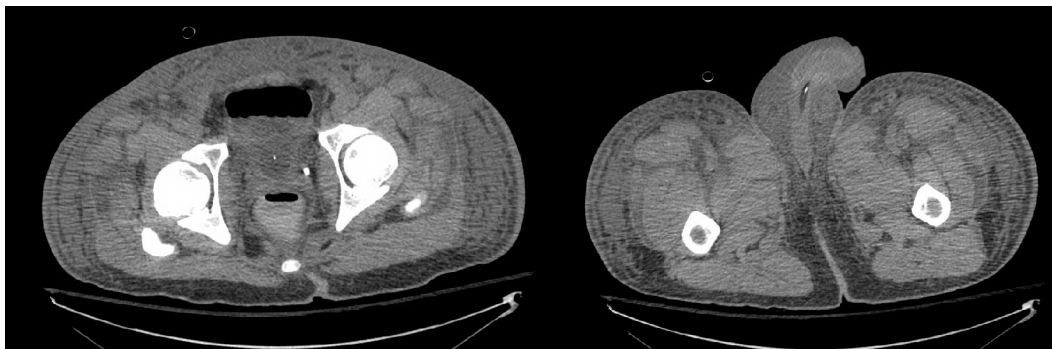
Computed tomography of abdomen and pelvis showing diffuse subcutaneous edema, along with edema seen between the muscle bundles in the abdomen and pelvis, fluid in pelvis and significant scrotal edema
